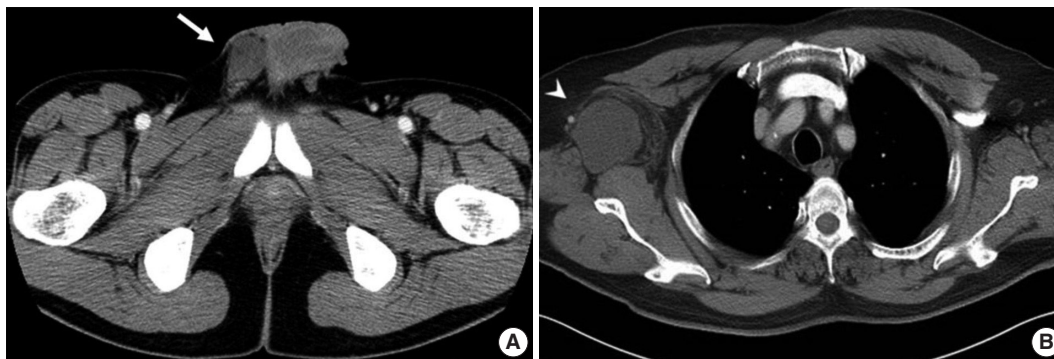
Radiologic findings for the two study cases. (A) In case 1, a pelvis computed tomography (CT) shows 5.0 cm mass in the right scrotal sac separated from the adjacent testis and spermatic cord (arrow). (B) In case 2, a chest CT shows a 5.5 cm lobulated mass in the right axilla (arrowhead).
